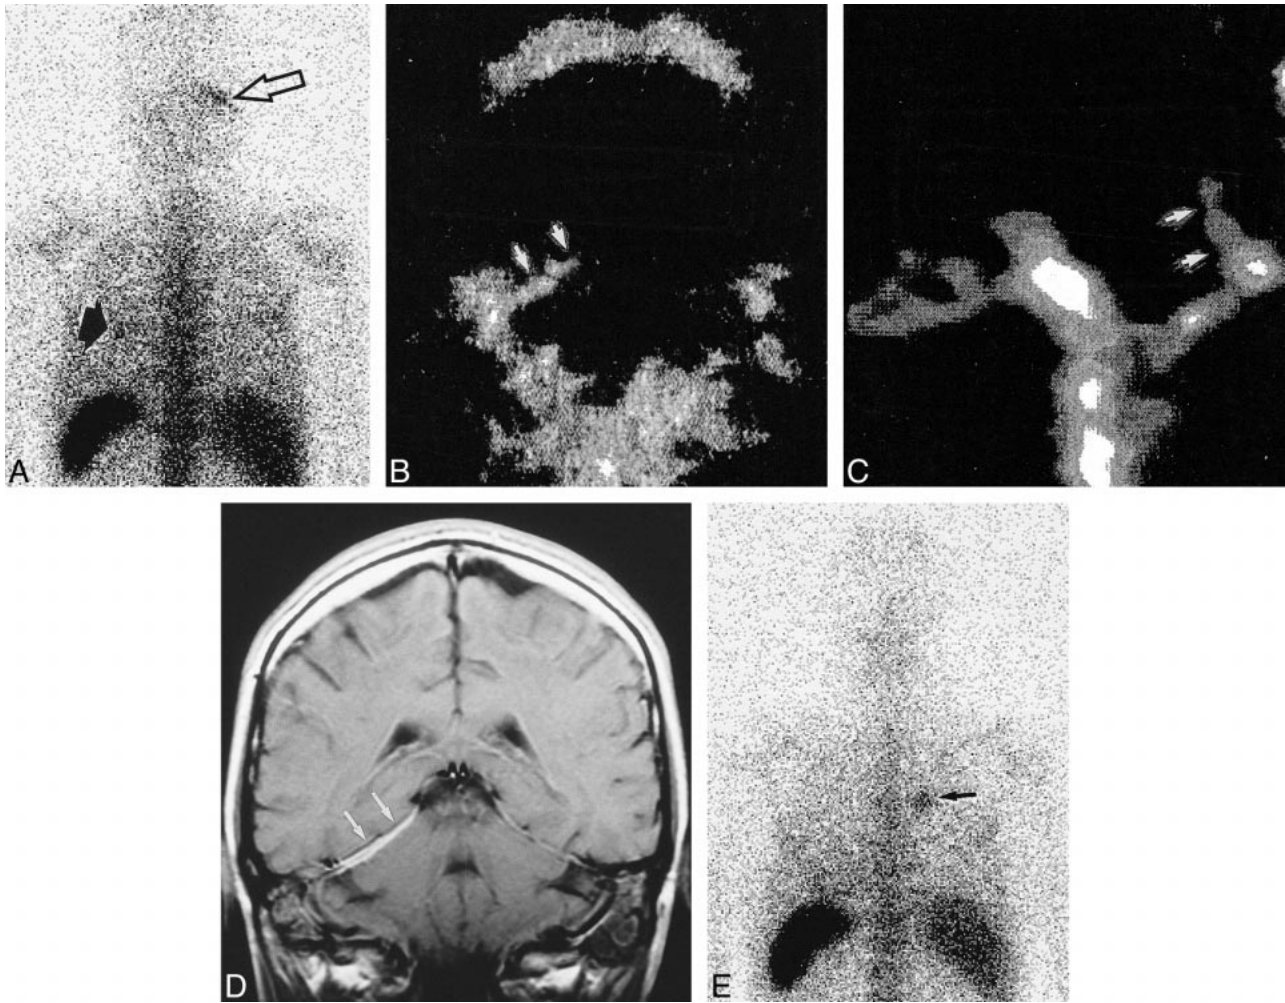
A, Posterior view at 24 hours from a ^{111}In -labeled leucocyte examination shows increased uptake in the right tentorium cerebelli (arrow). A focus of increased uptake is also visible in the left lung (arrowhead), which correlated with a cavitating nodule on a high-resolution CT scan.
